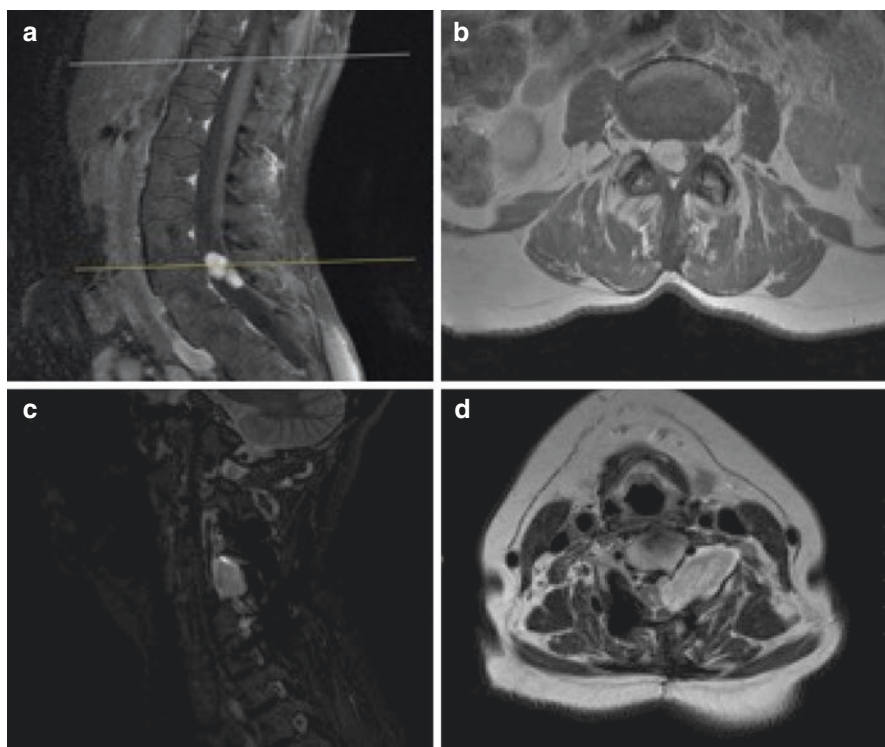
Images showing two patients with intradural tumors. T1-weighted sagittal (a) and axial (b) images of a patient with an exclusively intradural tumor. Sagittal (c) and axial (d) images of a patient with both intradural and extradural schwannoma
